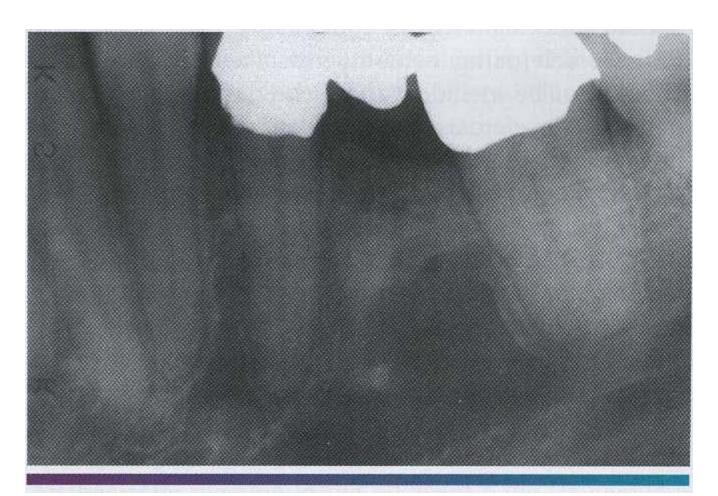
• Focal osteoporotic marrow defect. The periapical film shows a radiolucent area containing fine trabeculations. (Courtesy of Dr; Ed McGaha.)
